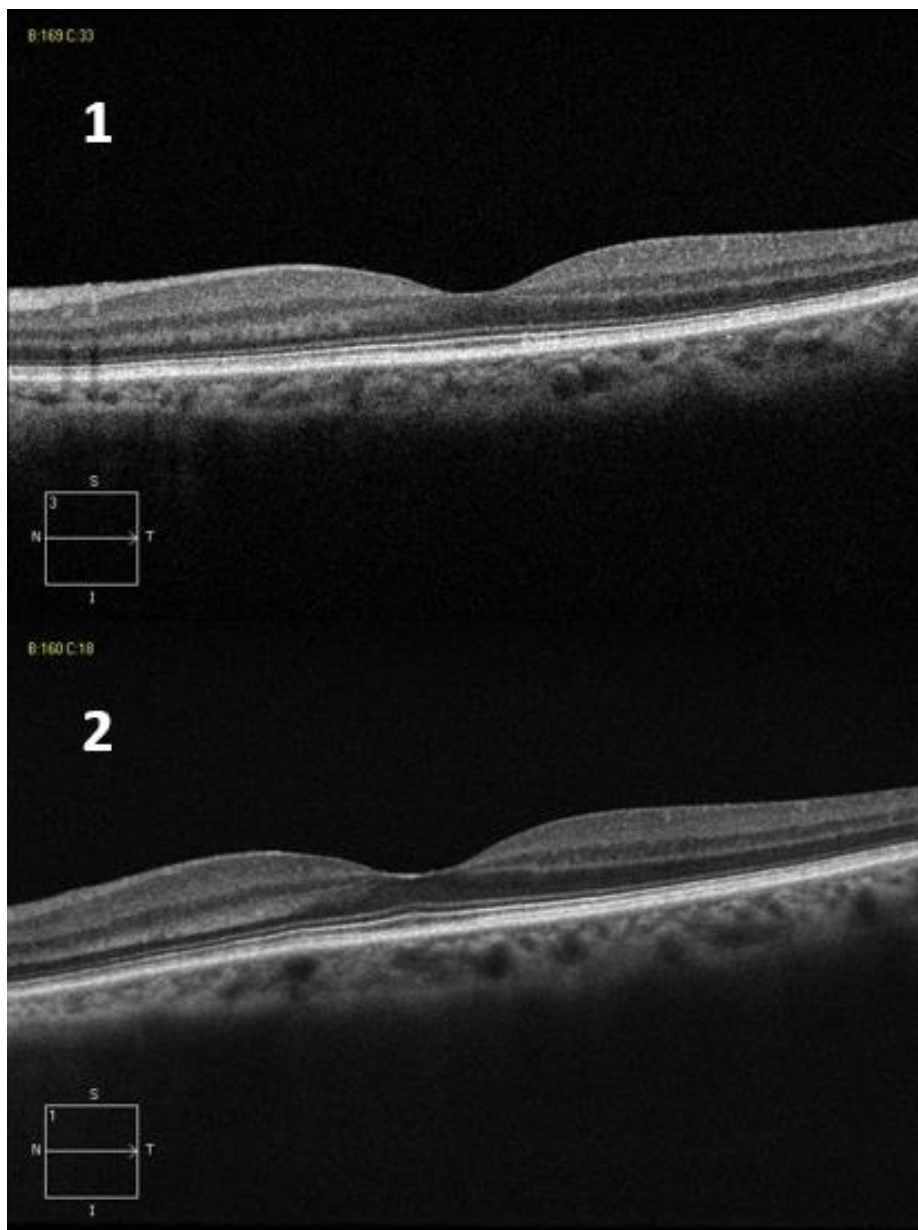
Example of CT increase with no retinal changes.
